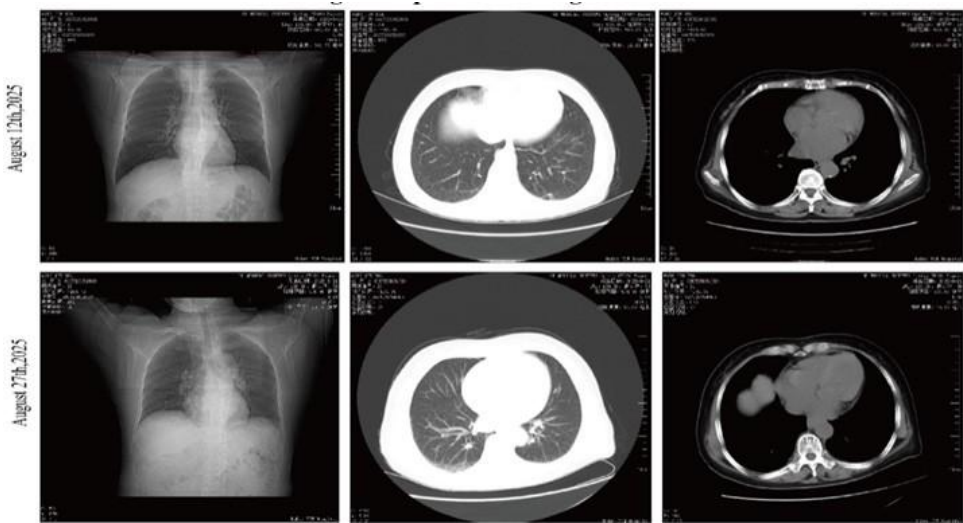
Comparison of Chest CT Scans Before and After Treatment. Left Lower Lobe (Posterobasal Segment, IM168): Possible focal infection. Both Lungs: Low-risk nodules; chronic bronchitis-like changes; minor dependent changes. Cardiovascular: Atherosclerosis of the aorta; calcifications along the coronary artery course; small amount of pericardial effusion.
